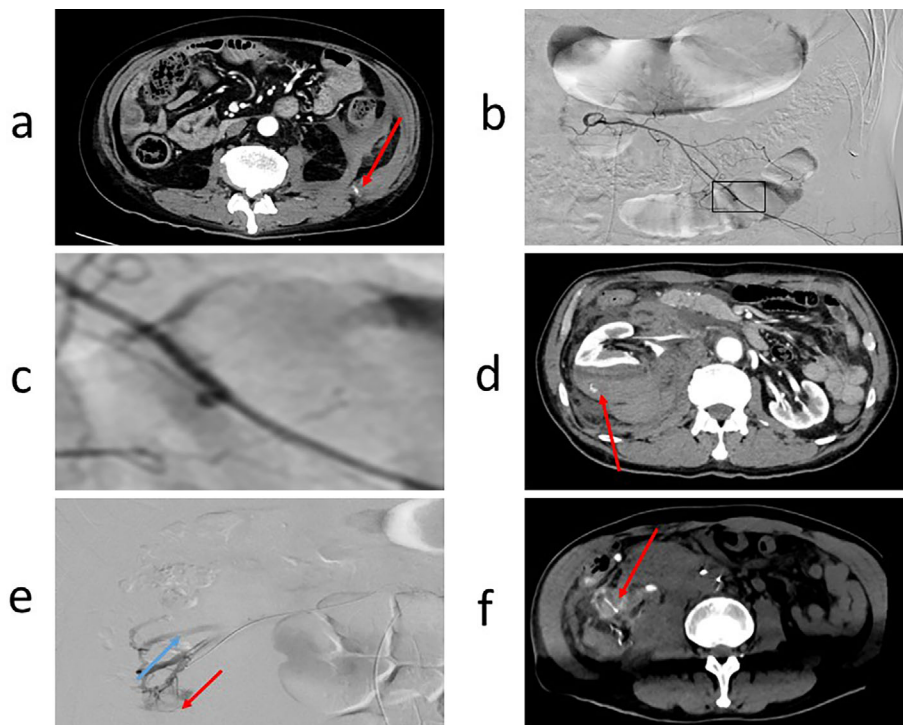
Computed tomography (CT) and angiography images in Patients 1 (a-c) and 2 (d-f). Patient 1: (a) Contrast-enhanced CT showing extravasation from the artery outside the kidney (red arrow). (b) Angiography revealing bleeding from the 12th subcostal artery. (c) Higher magnification of the fragment shown in (b). Patient 2: (d) Contrast-enhanced CT revealed hemorrhage in the hematoma (red arrow). (e) Angiography showing AVF formation between the branch of the renal artery feeding the lower pole (red arrow) and renal vein (blue arrow). (f) Contrast-enhanced CT during the second interventional radiology procedure. The vessel surrounding the right kidney is enhanced soon after injecting contrast media into the renal artery (red arrow). AVF: arteriovenous fistula
